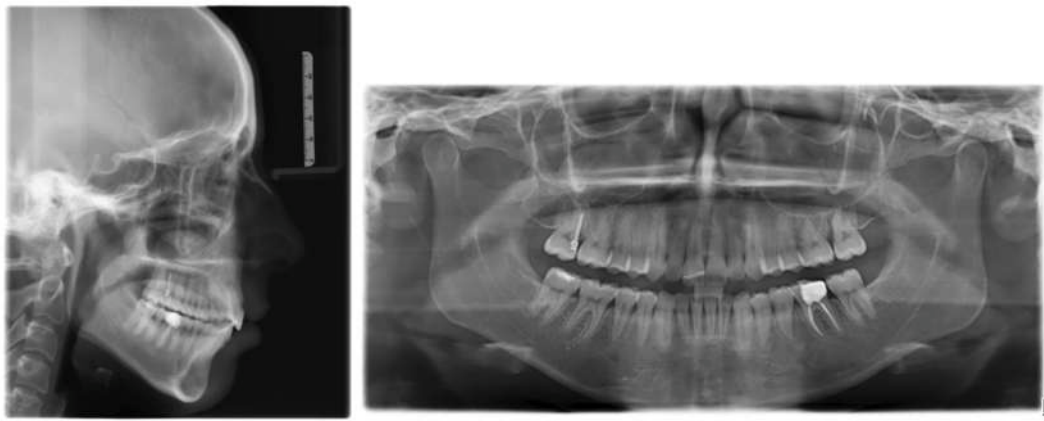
X-rays at the end of treatment.
